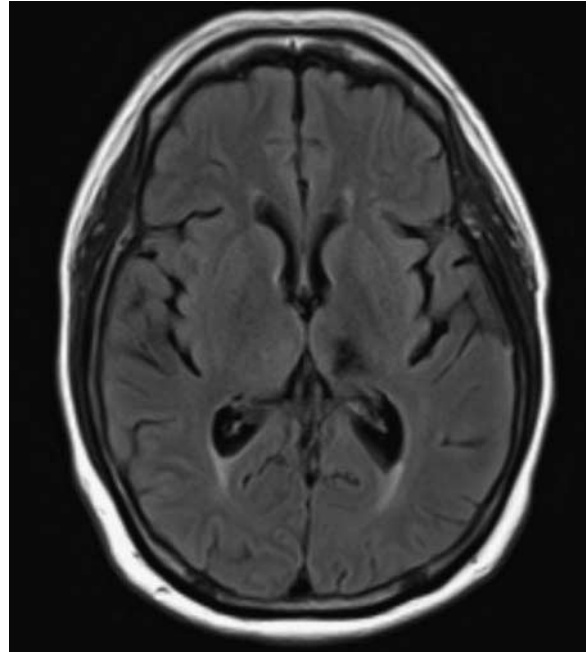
Three-month MRI showing the left thalamic encephalomalacia.
